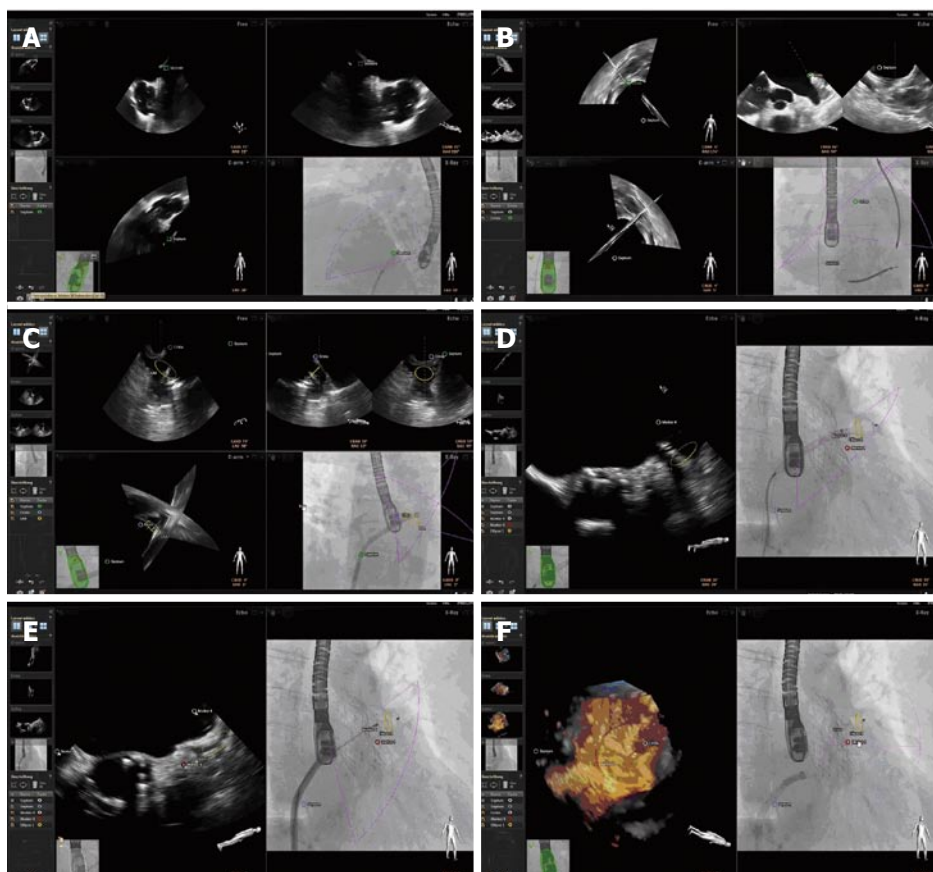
Echonavigator® during left atrial appendage occlusion. A demonstrates how the point of interest for potential transseptal crossing along the interatrial septum is marked in the Echo image. B demonstrates in the X-ray-view, that the wire is located cranial of the Crista terminalis, that initially was assigned in the Echo image. C depicts an ellipsoid ring, representing the landing zone for the occluder device marked yellow in the X-plane view of the 2D Echo image. D displays the deployment of the lobe of the left atrial appendage occluder, detecting that correct device size was chosen. E shows this ellipsoid marker right in between the lobe and the disc of the occluder after deployment of the disc. The red marker represents the location of the circumflex coronary artery. F shows the final result after disconnecting the guiding system from the occluder. The left panel gives a nice 3D overview of the site of implantation, displaying the difference of the landing zone (yellow circle) and the orifice area of the left atrial appendage.
